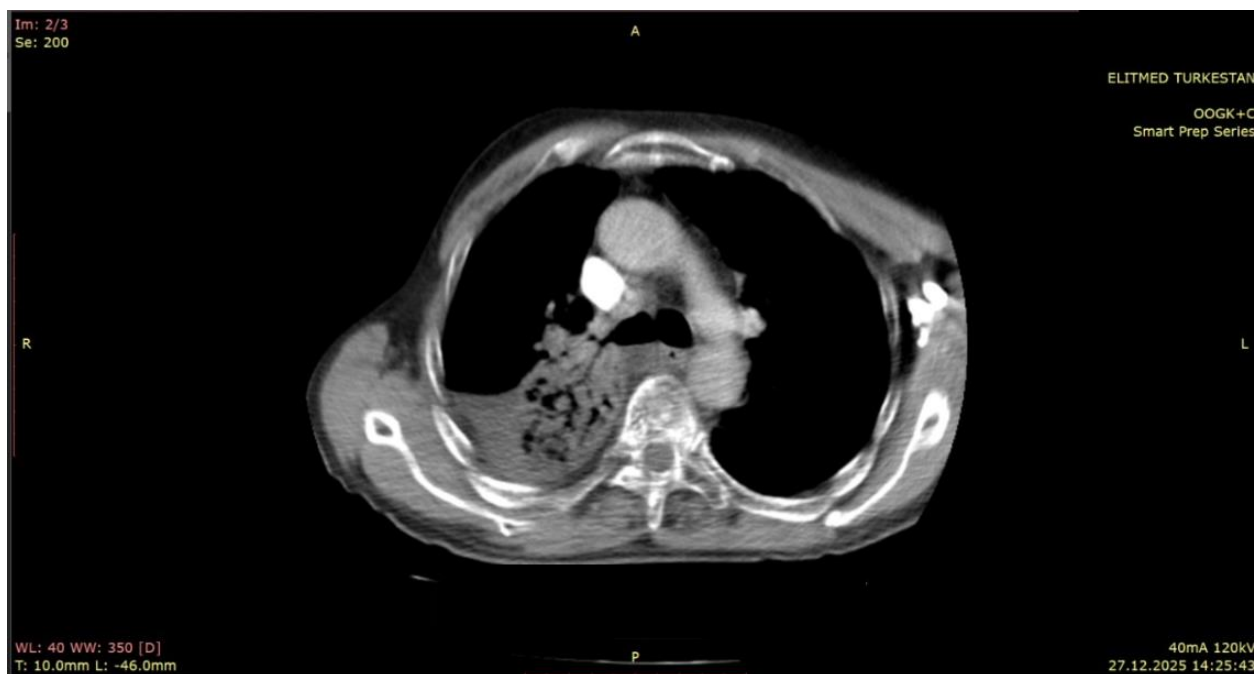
Representative axial contrast-enhanced chest CT image acquired on 27 December 2025 after chemotherapy and thoracic radiotherapy and before durvalumab initiation. The image is provided for clinical context; RECIST-compatible target-lesion measurements were unavailable. Patient-identifying information was removed. Source: authors' clinical archive.
